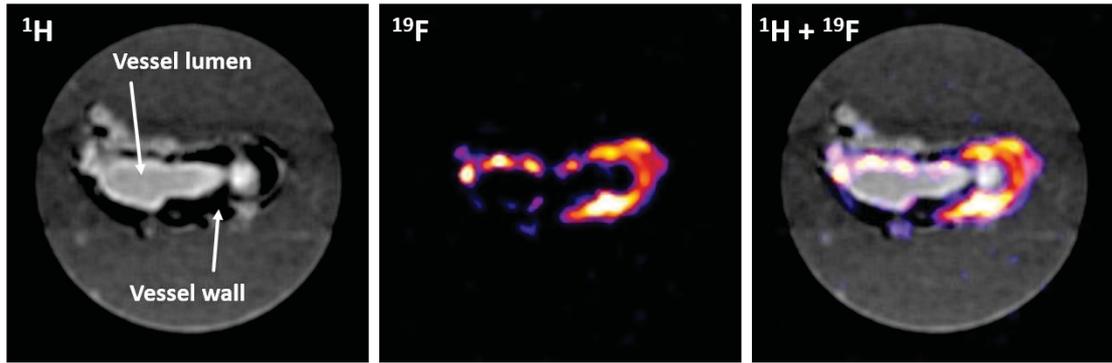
Representative pictures of $^1\text{H}/^{19}\text{F}$ MRI measurement from the isolated aorta.
